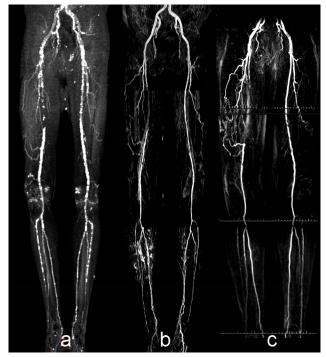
An 82 year old man, explored for a pre-occlusive stenosis of the right superficial femoral artery, with CTA (a), CE-MRA (b) and FBI (c). The images are scored as good for CTA and FBI but only mid for CE-MRA because of venous and background contamination. The stenosis is well depictedin all 3 techniques. There is an artifact on the left iliac artery due to the oblique angle of the vessel and there are many calcifications which obstruct the visibility of the lumen on CTA. There are many wall plaques with a low flow in calf arteries, particularly in the right anterior tibial artery and the left peroneal artery.
